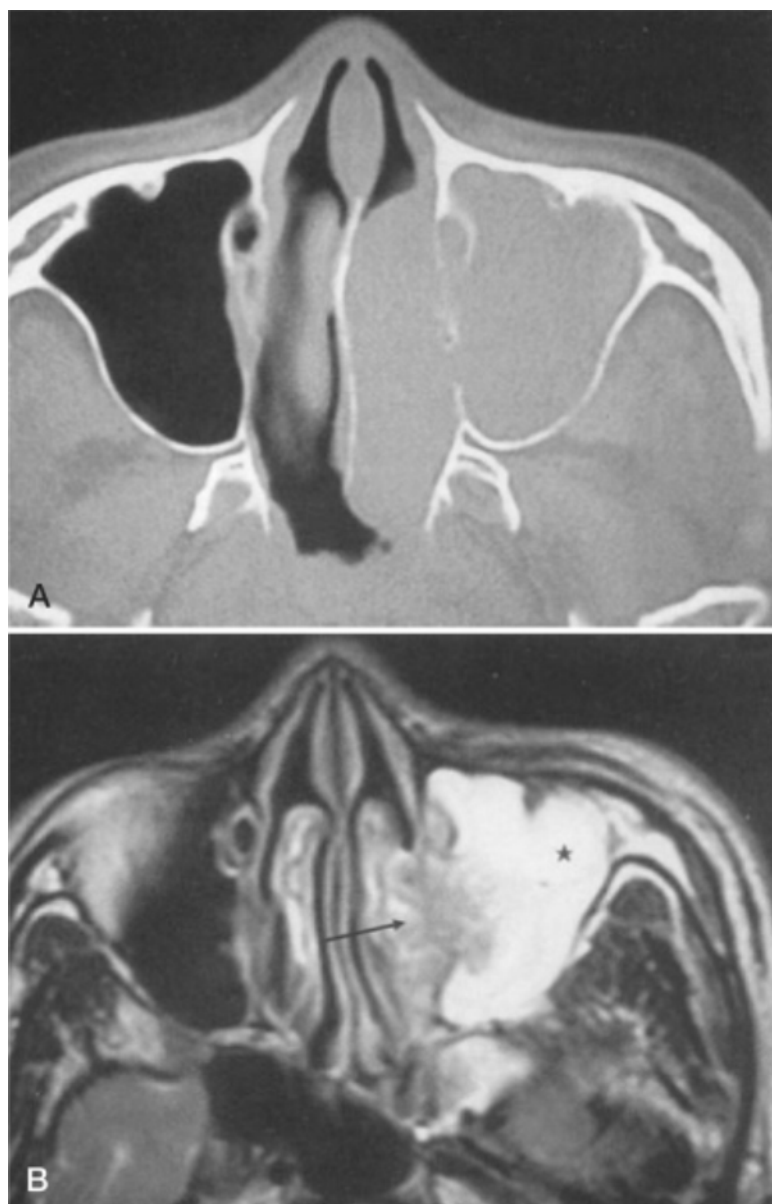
A, Coronal computed tomography (CT) demonstrating opacification of the left-sided maxillary sinus. With CT images it is difficult to determine which portion of the opacification represents the tumor and which represents obstructed secretions. B, Coronal T2-weighted magnetic resonance image demonstrating an inverted papilloma as an intermediate-signal intensity mass (*arrow*) involving the medial portion of the left maxillary sinus. High-signal intensity (*star*) indicates the obstructed secretions in the left maxillary sinus. (Reprinted with permission from Oikawa K, Furuta Y, Oridate N, et al: *Preoperative staging of sinonasal inverted papilloma by magnetic resonance imaging. Laryngoscope* 113:1985, 2003.)
